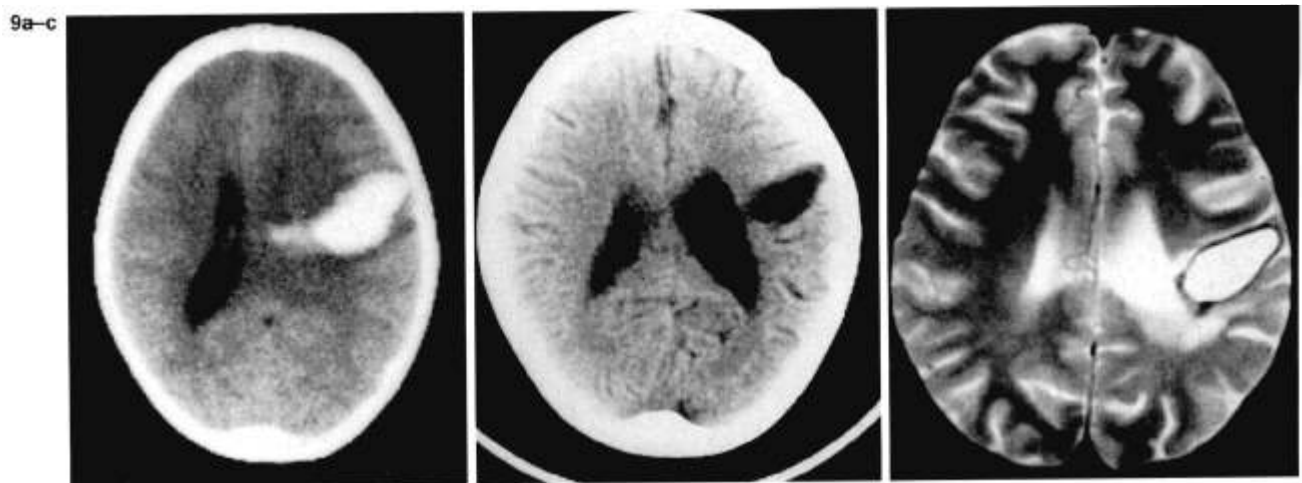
Four year sequela of hemispheric hematoma at 1.5 T. In 1984 CT (a) shows left hematoma, the sequela of which, 4 years later (b), is evident as a porencephalic cavity. At this time (c) T2-weighted image (TR 2,500/TE 80) shows fluid filled cavity with hypointense hemosiderin/ferritin rim and peripheral hyperintensity (gliosis). T1-weighted image (not available) would similarly show hypointensity characteristic of fluid.
